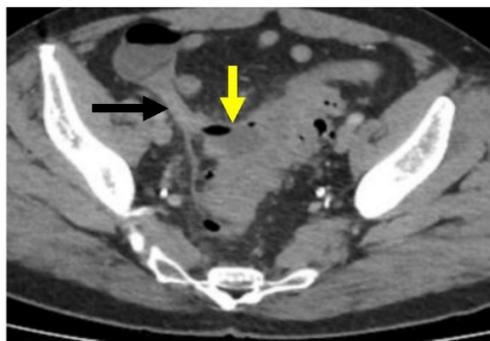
Acute sigmoid diverticulitis complicated by peridiverticular abscess. Axial CT with IV contrast through the pelvis. There is a rim-enhancing collection of fluid and air along the medial wall of the sigmoid colon (yellow arrow), compatible with abscess. This also abuts the appendix (black arrow), with possible fistulous communication.
